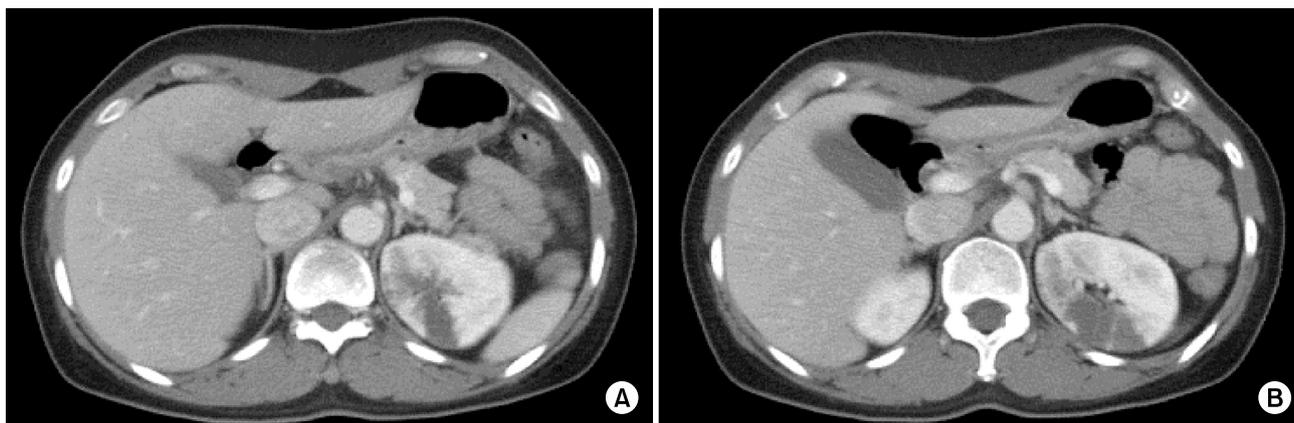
(A) The enhanced abdominal computed tomography (CT) scans showed a multifocal wedge shaped perfusion defect of the left upper portion of the kidney. (B) Enhanced abdominal CT scans showed a multifocal wedge shaped perfusion defect of left interpolar portion of the kidney.
